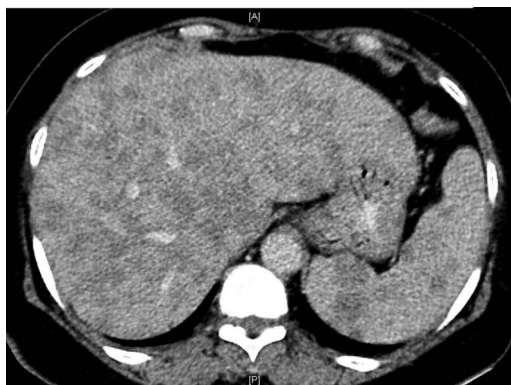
CT scan of the abdomen extensive involvement of liver and spleen.
